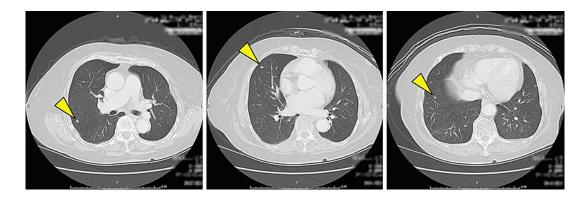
Six months after the small pulmonary nodule had been detected, computed tomography showed that the nodule had grown and become clearer, and new pulmonary nodules had appeared (arrowheads; tumor diameters: 6, 7, and 5 mm, respectively).
